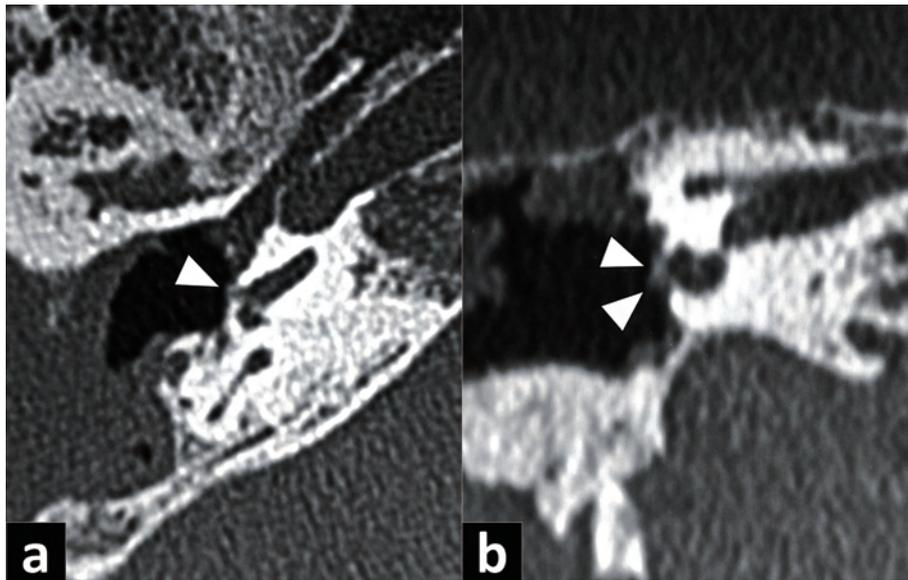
The axial (a) and the coronal (b) CT scan clearly showed the fistula in the cochlea (arrow head).
